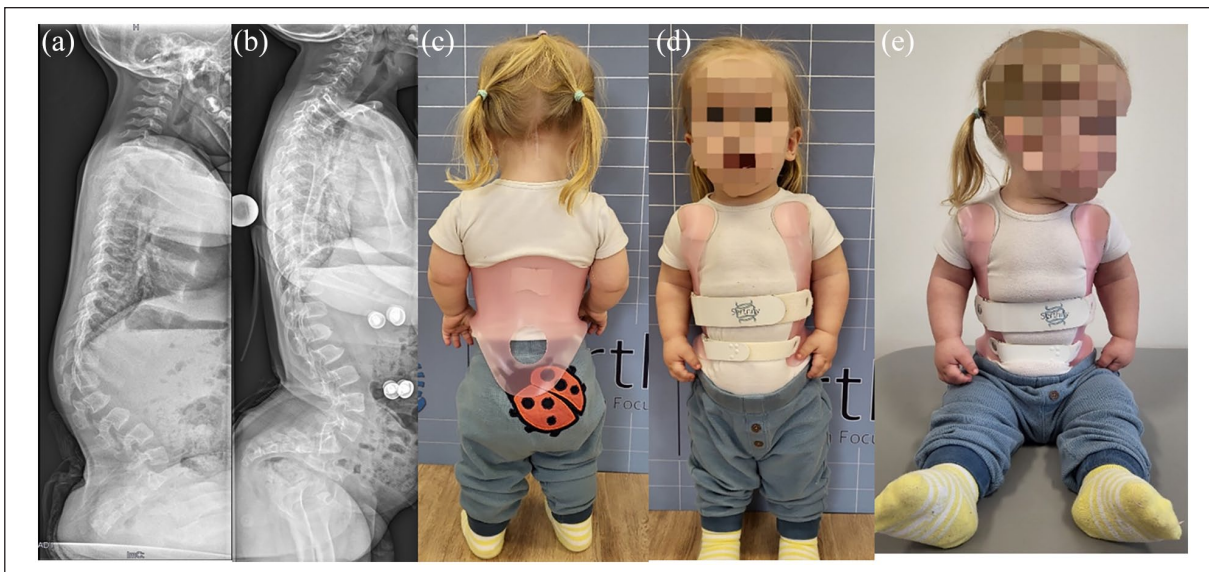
Three-year-old female with achondroplasia: (a) persistent lumbar kyphosis despite improvement of muscular trunk stability, (b) radiograph with a brace (note: severe lumbosacral lordosis with and without brace) and (c)–(e) clinical picture with a brace.
